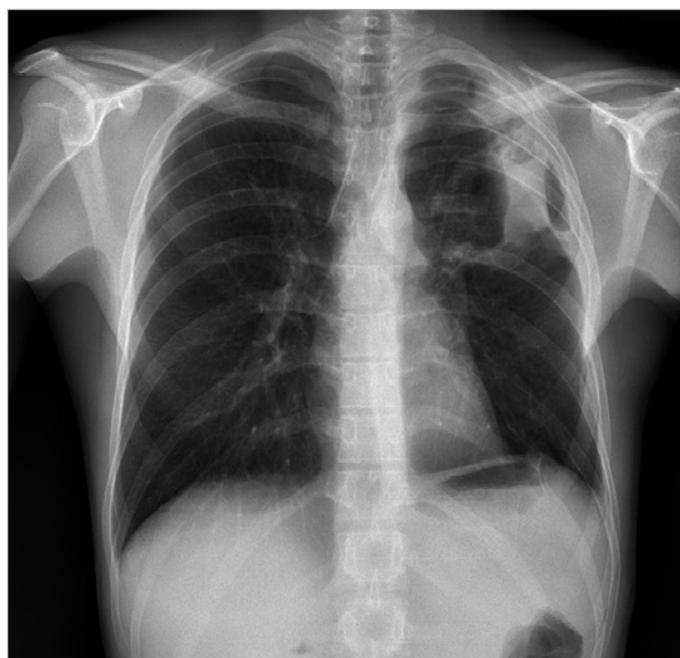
Chest X-ray after surgical treatment.
